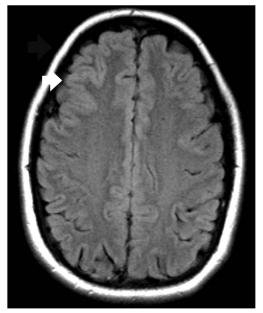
MRI (Axial FLAIR) demonstrates very mild hyperintense signal with gyral swelling in right frontal cortex (arrow).
